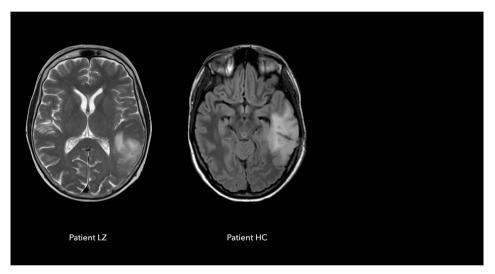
Magnetic Resonance Imaging of patients with gliomas in the temporal lobe. Pre-operative MRI scans are presented for two patients with temporal lesions. Patient LZ: high-grade glioma in the posterior part of the middle and inferior temporal gyrus. Patient HC: low-grade glioma in the posterior part of the inferior temporal gyrus.
